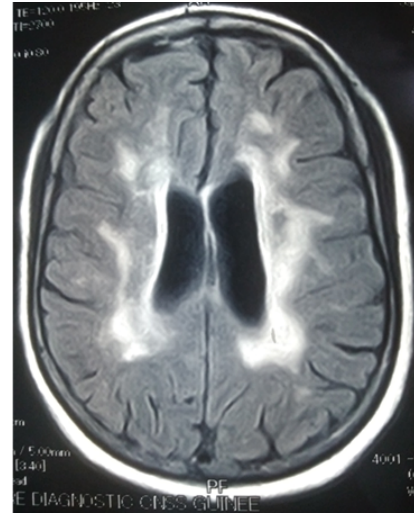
MRI axial section (T2 Flair sequence): Periventricular hypersignals with extension into multiple, confluent white matter (Fazekas score 3).
